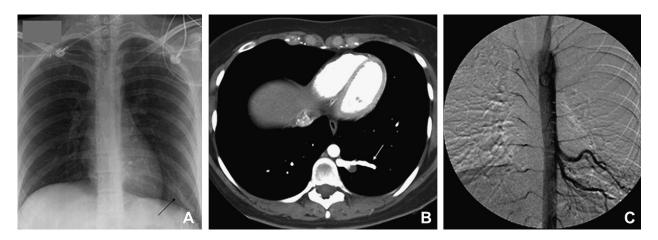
Initial imaging tests. Anteroposterior thoracic X-ray (A), the *black arrow* points to the opacity band at the base of the left hemothorax. Computed tomography angiography (B), *white arrow* points to the anomalous inflow vessel arising from the thoracic aorta and crossing
